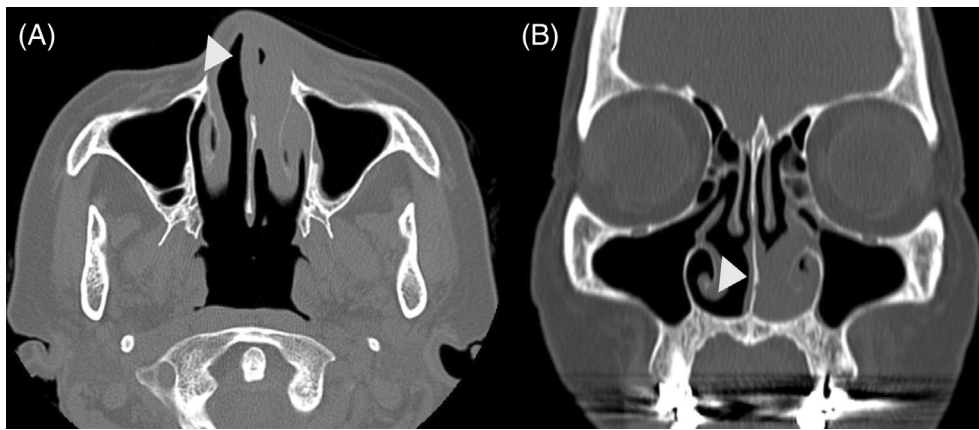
A 67-year-old female presenting with left nasal swelling with associated epistaxis and anterior drainage diagnosed with SN-NKTL. (A) Axial and (B) coronal CT sinus without contrast demonstrating a soft tissue mass (yellow arrowhead) filling left anterior nasal cavity and obliterating the inferior meatus without evidence of bony erosion or mucosal thickening within the sinuses
